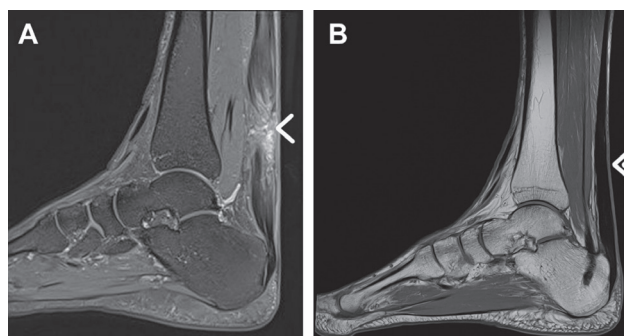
A - MRI of the patient with chronic degenerative Achilles tendon rupture (arrow <). B – MRI of the same patient 5 years after FHLT transfer. There is obvious full restoration of Achilles tendon structure (double arrow <<) and one can notice hypertrophy of FHLT.
